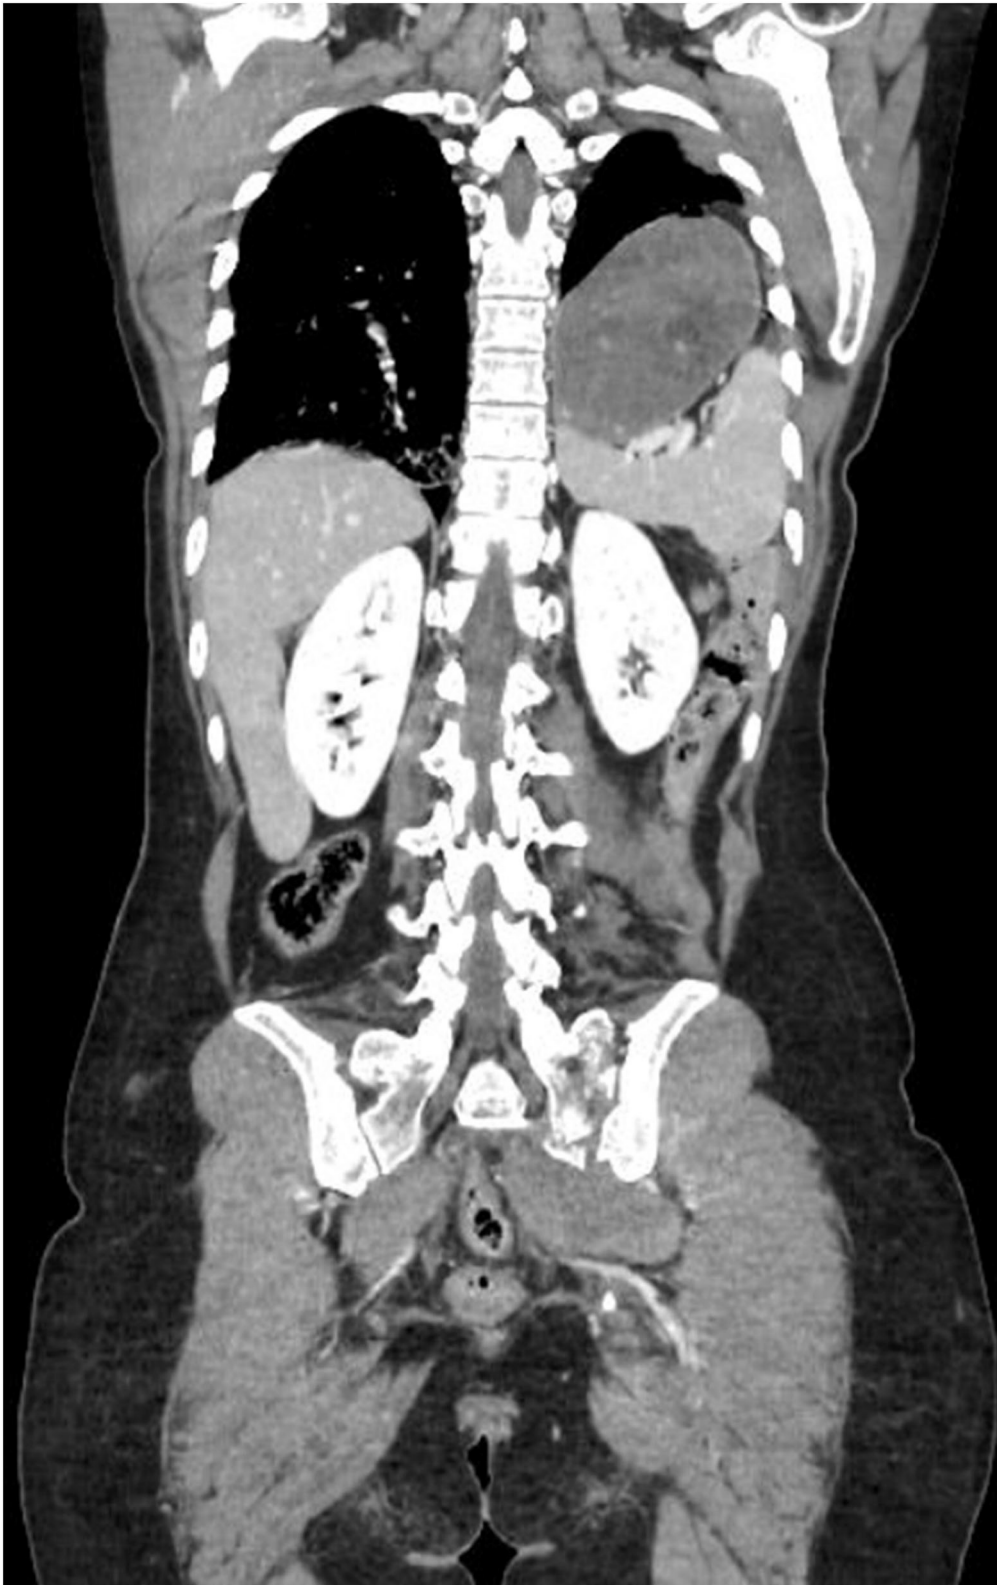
Preoperative Thorax-Abdomen contrast-enhanced CT, showing left postero-lateral diaphragmatic lesion involving the left diaphragmatic pillar and the herniation of the stomach and the spleen in thorax, associated with a lung parenchyma compression and dislocation of the mediastinum.
